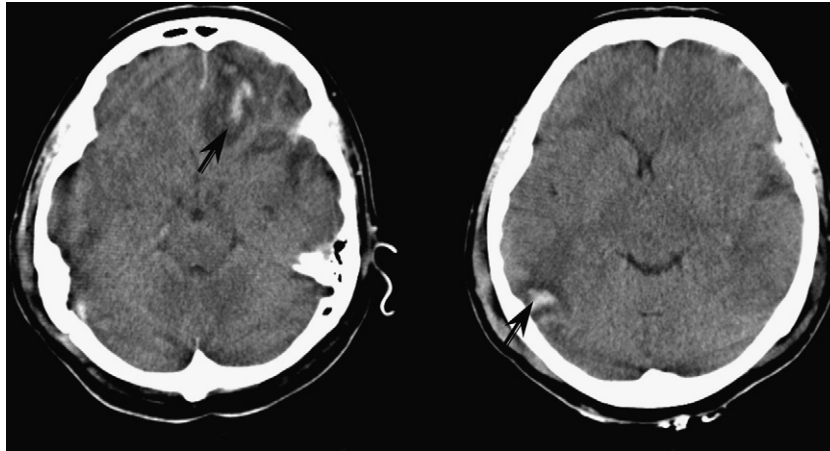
CT revealing a large left frontal contusion with an associated right parietal lobe contusion in the location of a contra-coup injury (arrows).
